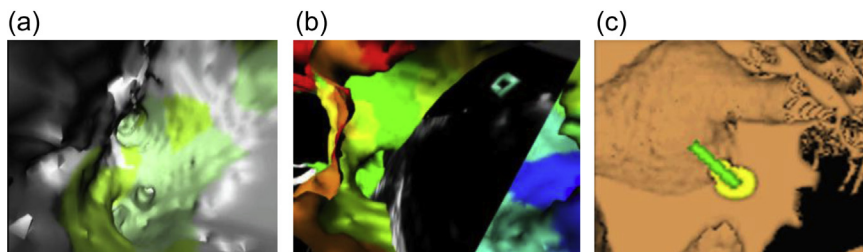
Example of electro-anatomical model of the left atrium showing (a) the activation times at one of the pulmonary vein bifurcations, also complemented (b) with real-time ultrasound imaging. (c) Volume-rendered representation of the ablation lesion modeled via the image-based thermal model superimposed onto the preoperative volume-rendered anatomy.
